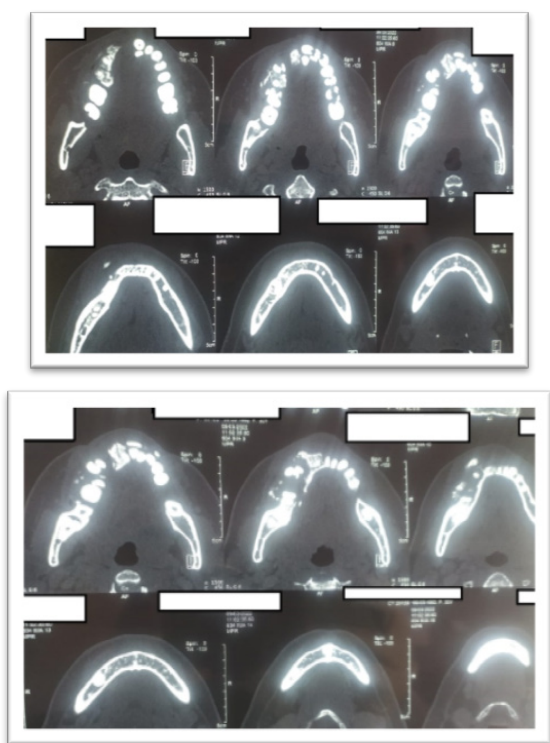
CT images of the tumor in axial section.
